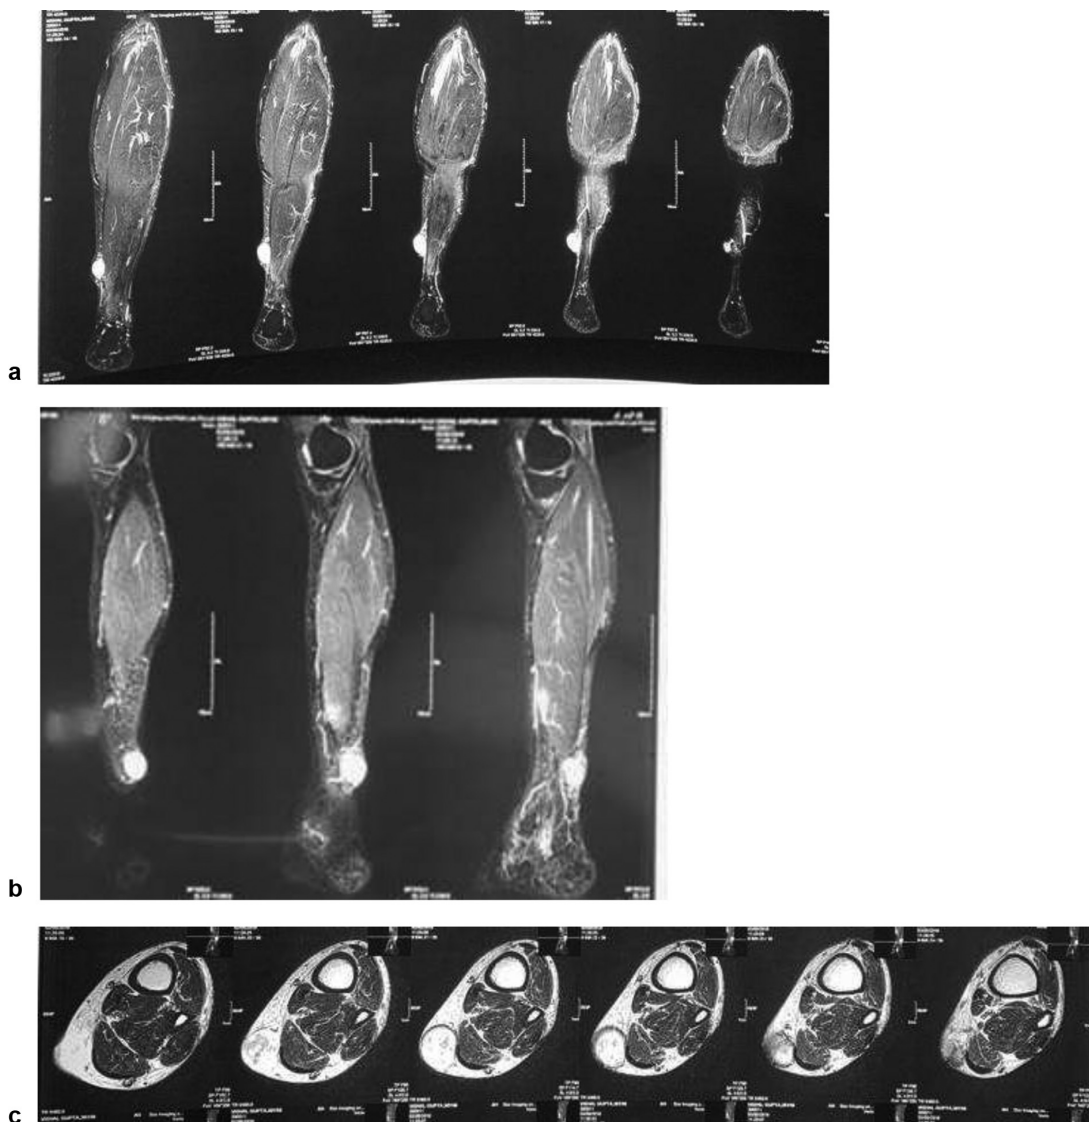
(a) Magnetic resonance imaging scan (MRI) showing posteromedial swelling over the distal third of the leg in coronal view. (b) MRI showing posteromedial swelling over the distal third of the leg in sagittal view. (c) MRI showing posteromedial swelling over the distal third of the leg in axial view.
